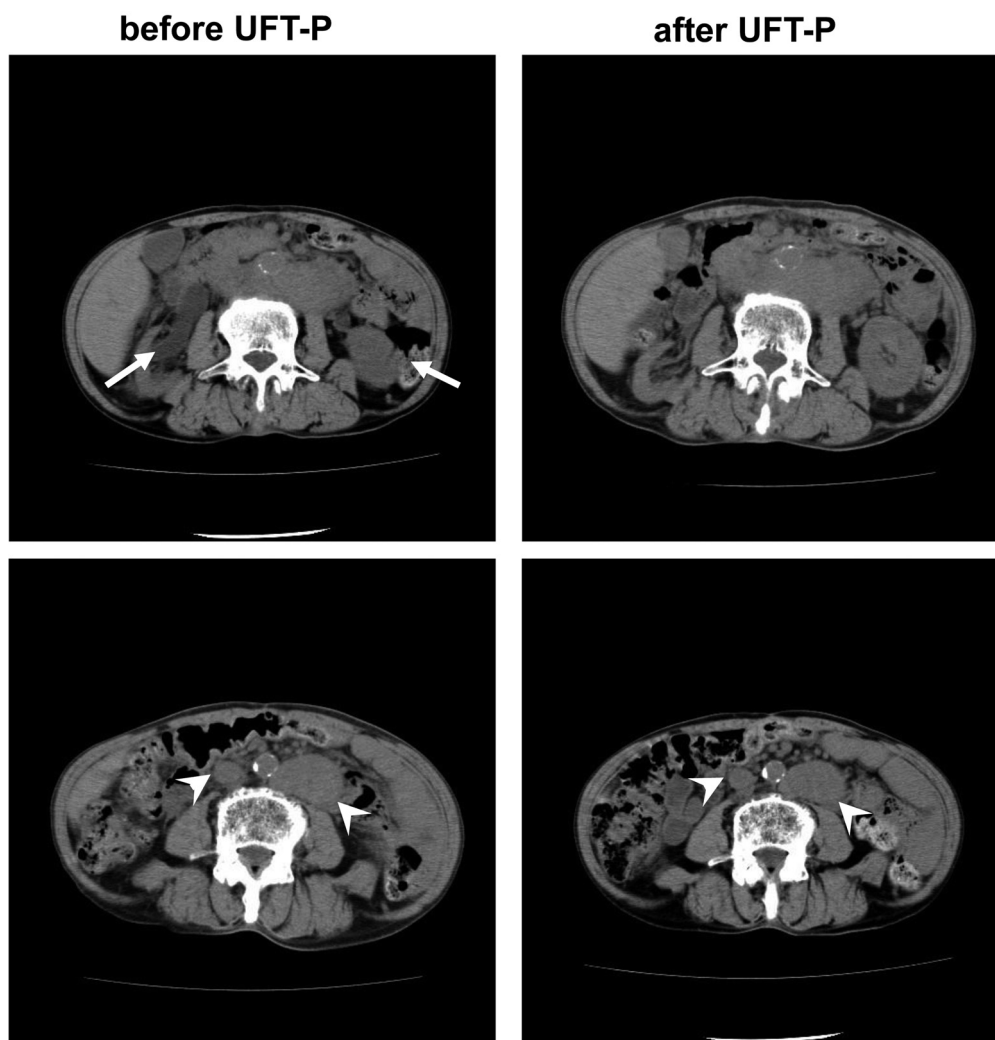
Computed tomography scans, indicating that bilateral hydronephrosis resolved in association with shrinkage of lymph node metastases after UFT-P therapy. The arrows indicate hydronephrosis and the arrowheads indicate lymph node metastasis.
